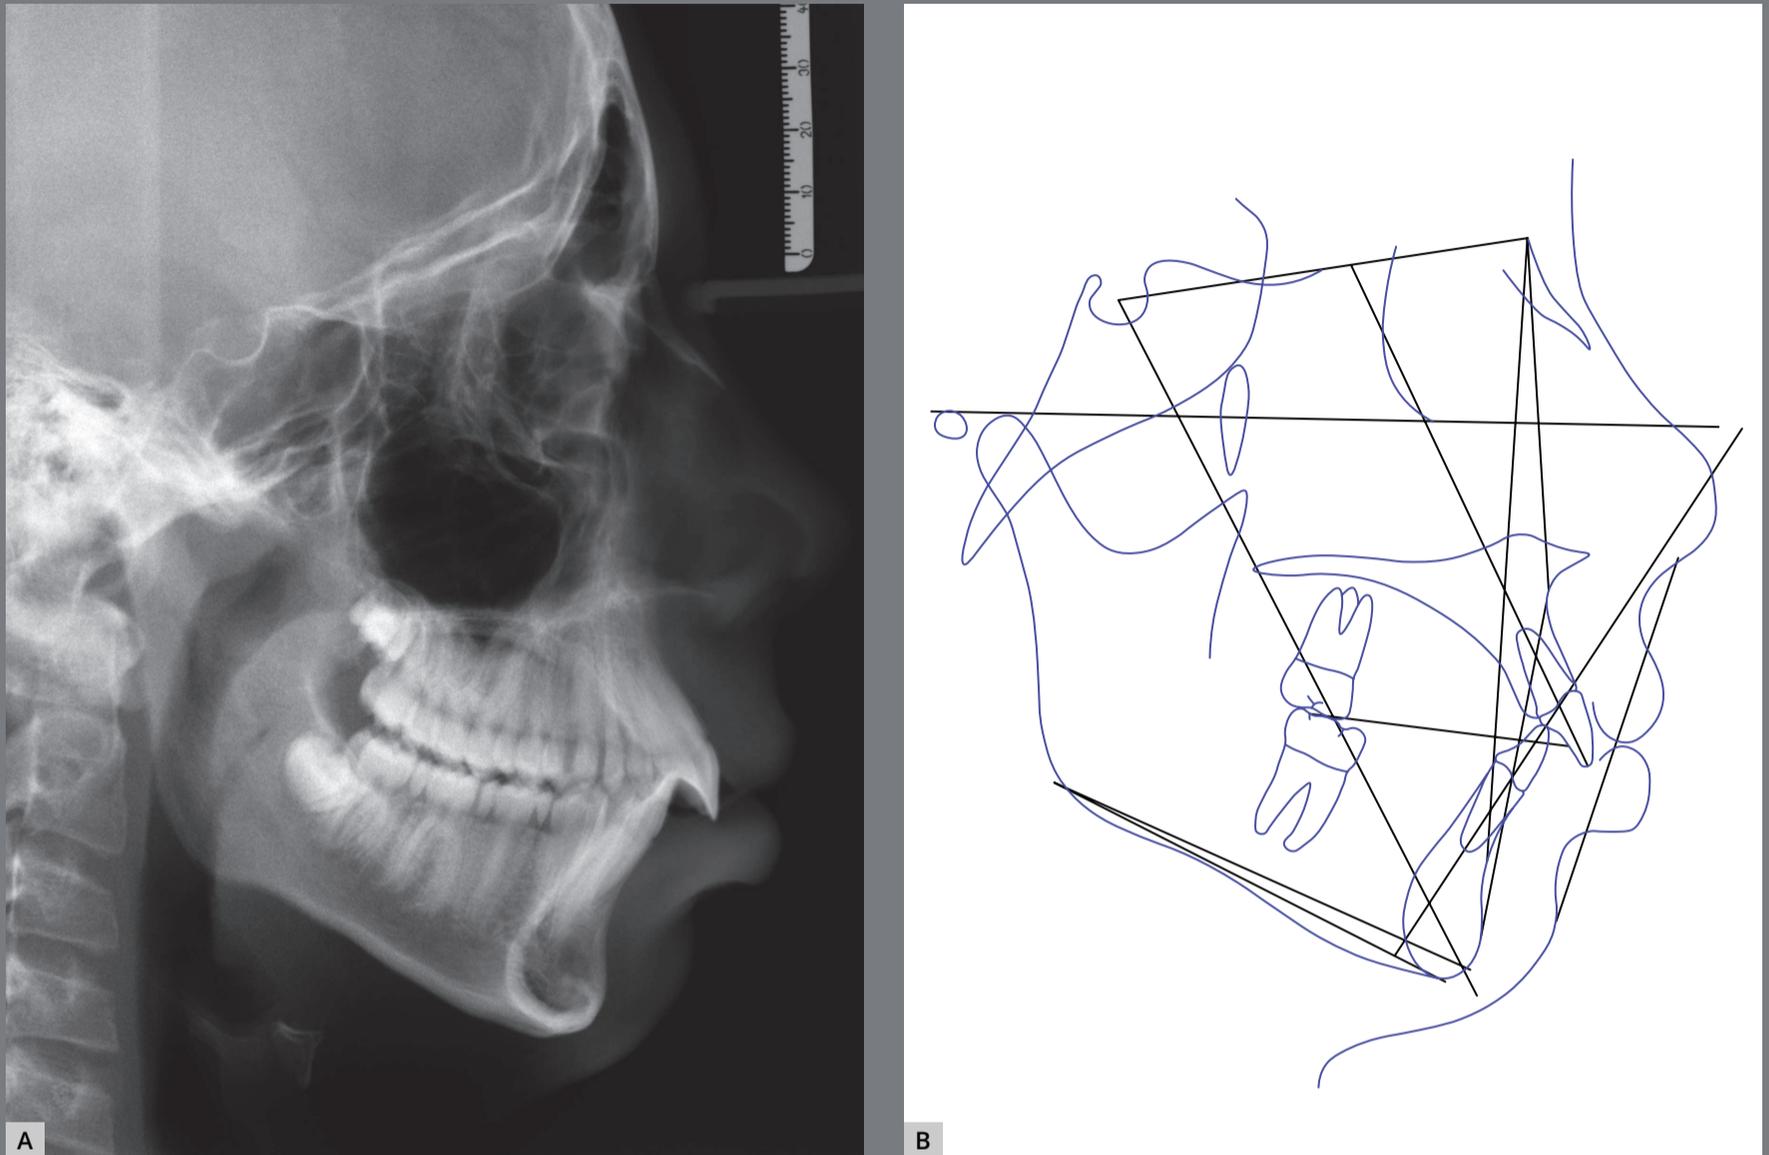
Intermediate cephalometric radiograph of facial profile (A) and cephalometric tracing (B) after Phase 1.
